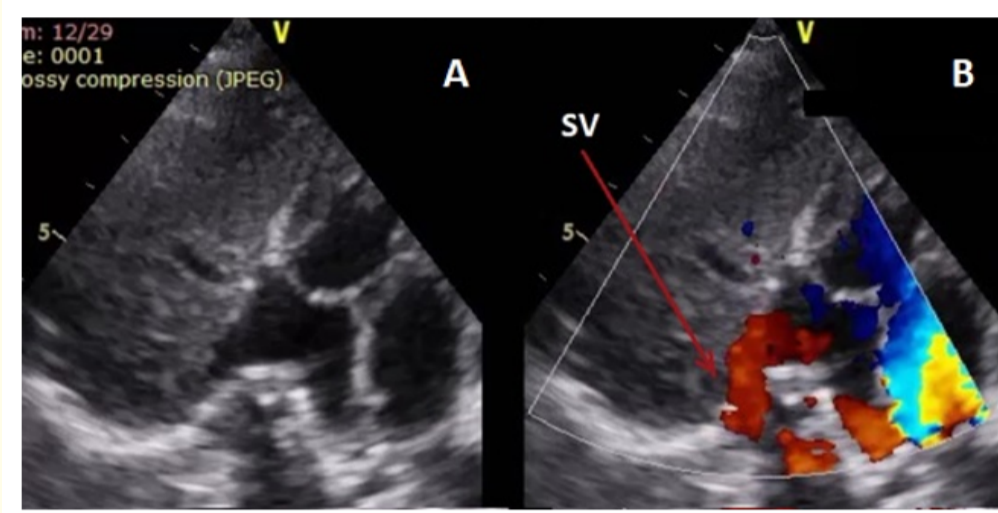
Transthoracic echocardiography subcostal bicaval view (A) 2D and (B) with color Doppler showing a vascular structure with a directed flow towards the inferior vena cava suggestive of scimitar vein. *SV: Scimitar vein.
